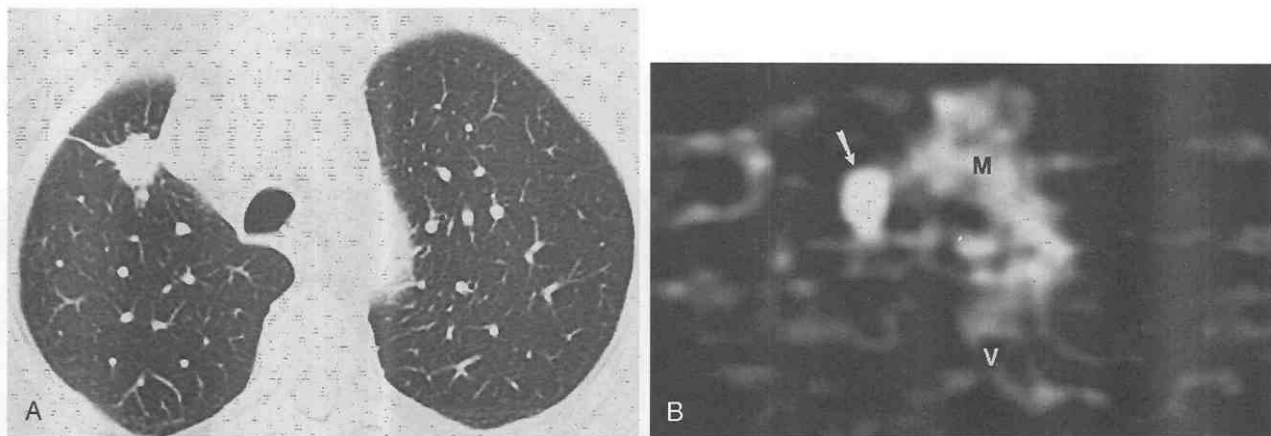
Non-small-cell lung cancer seen as hypermetabolic nodule on a PET scan with ¹⁸F-fluorodeoxyglucose (FDG-PET). *A*, CT scan shows a nodule in the right upper lobe. The irregular margin suggests malignancy. *B*, Axial PET image with FDG shows increased uptake within the nodule (arrow) when compared to adjacent mediastinum. Findings suggest malignancy. Resection revealed squamous cell cancer. M, mediastinum; V, vertebral body.
